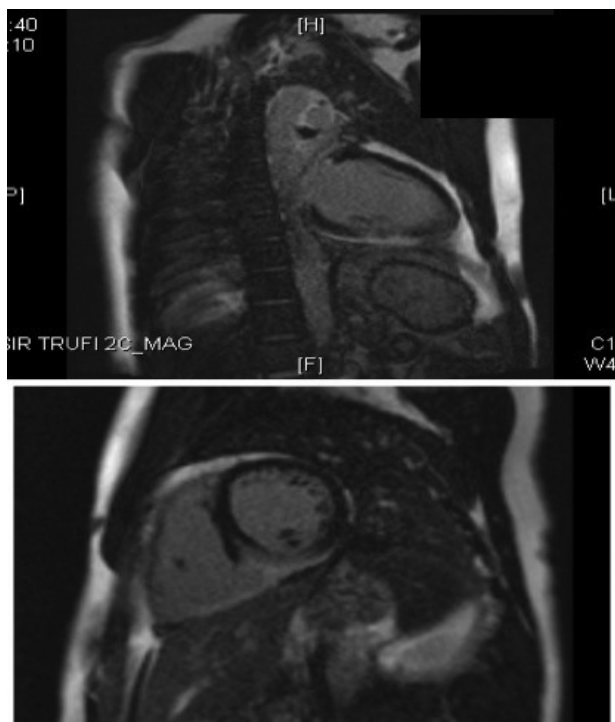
Cardiac MRI: mid-myocardial and epicardial delayed Gadolinium enhancement in infero-septum and LV inferior wall from mid-chamber to the apex, adjacent delayed enhancement of inferior wall of RV. LVEF was 61%.
